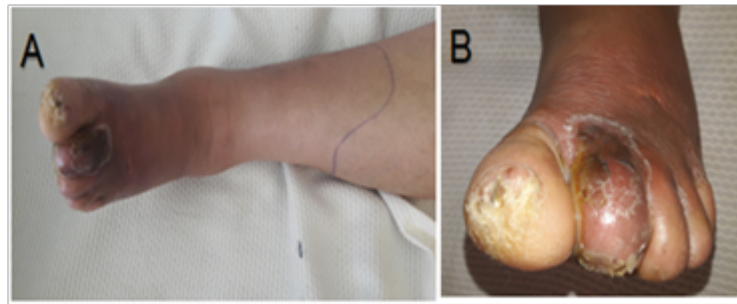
(C, D). Standard radiography of the left foot showed hypoplasia of the second phalanx with absence of the last phalanx of the four toes and hypoplasia of the last phalanx of the first toe.
